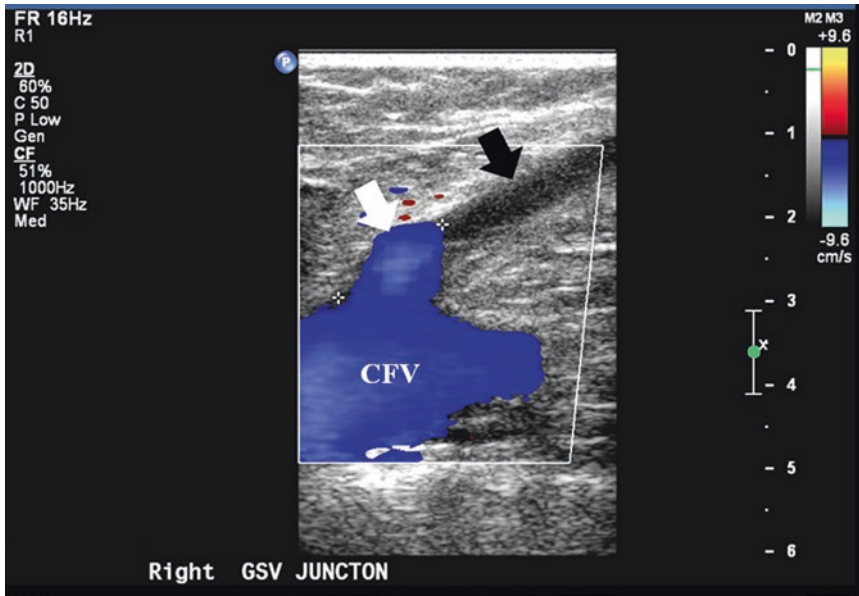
After treatment is completed, color duplex ultrasound demonstrates continued cephalad flow and compressibility in the common femoral vein (CFV) and in the remnant patent portion of the GSV (*white arrow*).
